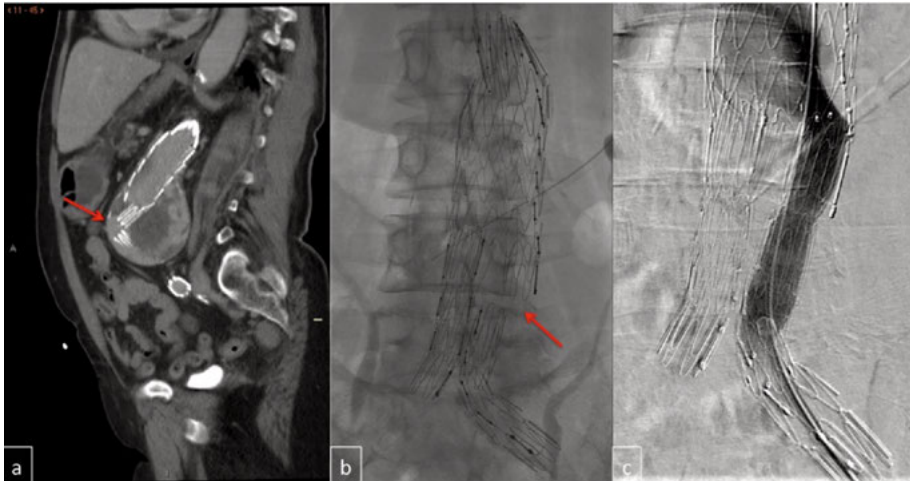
Endoleak type III due to component separation on CTA (a) and DSA (b), management with by bridging the gap between the two components (c).
